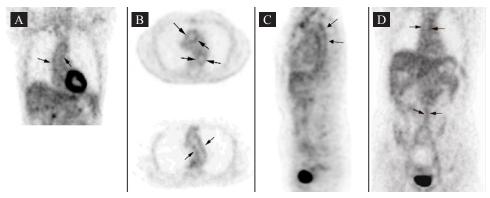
18F-FDG uptake in the ascending aorta, arch of aorta, descending thoracic and abdominal segments of the aorta (arrows) on coronal (A, E), axial (B, C), and sagital (D) slices. Mean SUV were calculated using axial slices (B, C).
